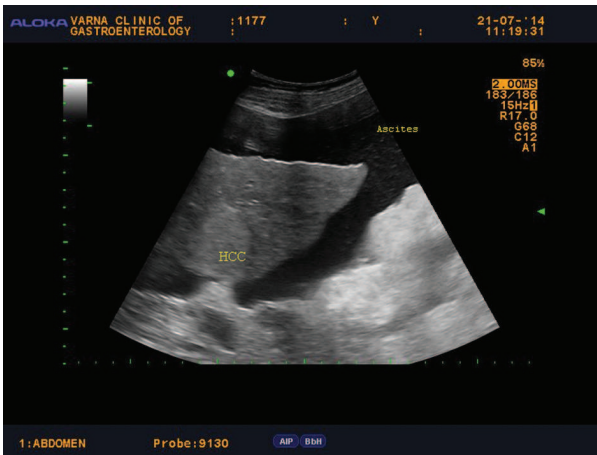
Abdominal ultrasound findings in patient with decompensated viral cirrhosis
